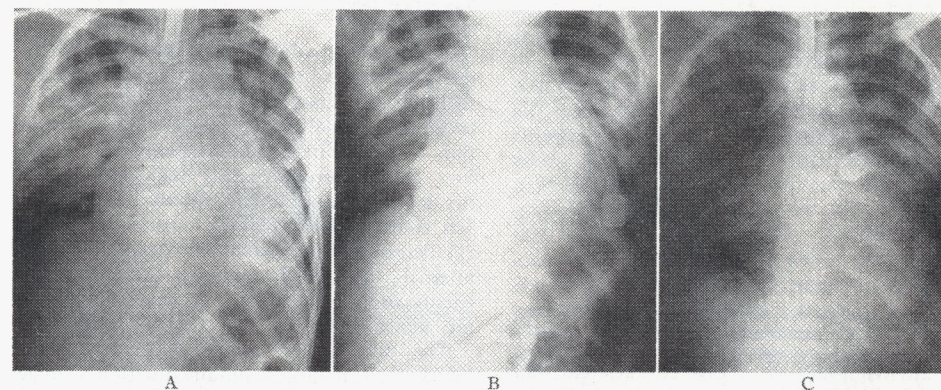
A, chest roentgenogram after cardiac massage showing severe pulmonary edema. B, x-ray evidence of pulmonary edema clearing six hours after inserting artificial left ventricle. C, pulmonary edema cleared forty-eight hours after inserting artificial left ventricle.
